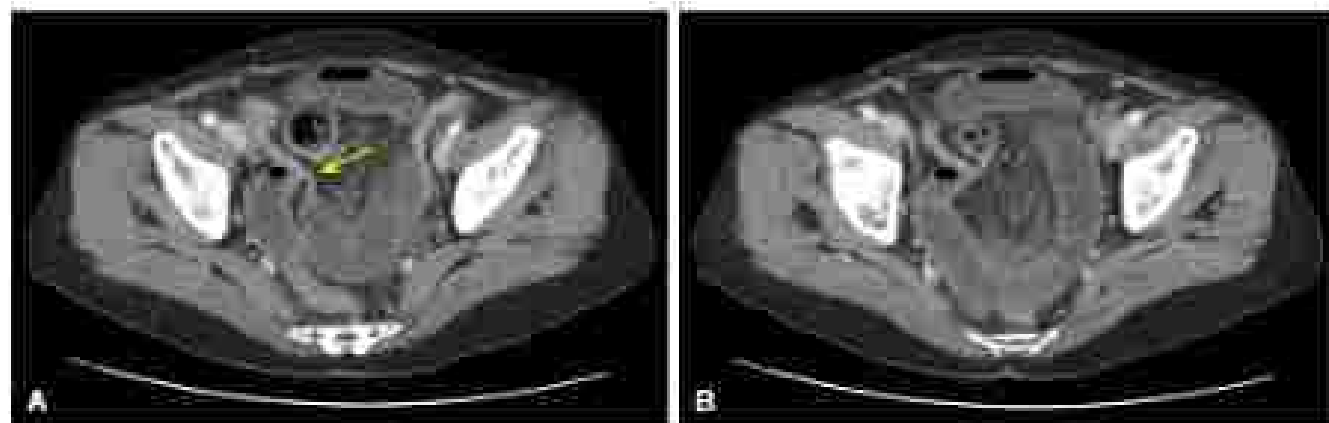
Computed tomography images of a patient demonstrating findings consistent with a closed-loop obstruction. (A) One clear transition point is visible adjacent to (B) a second transition point, not also clearly visible, suggesting closed loop obstruction.
